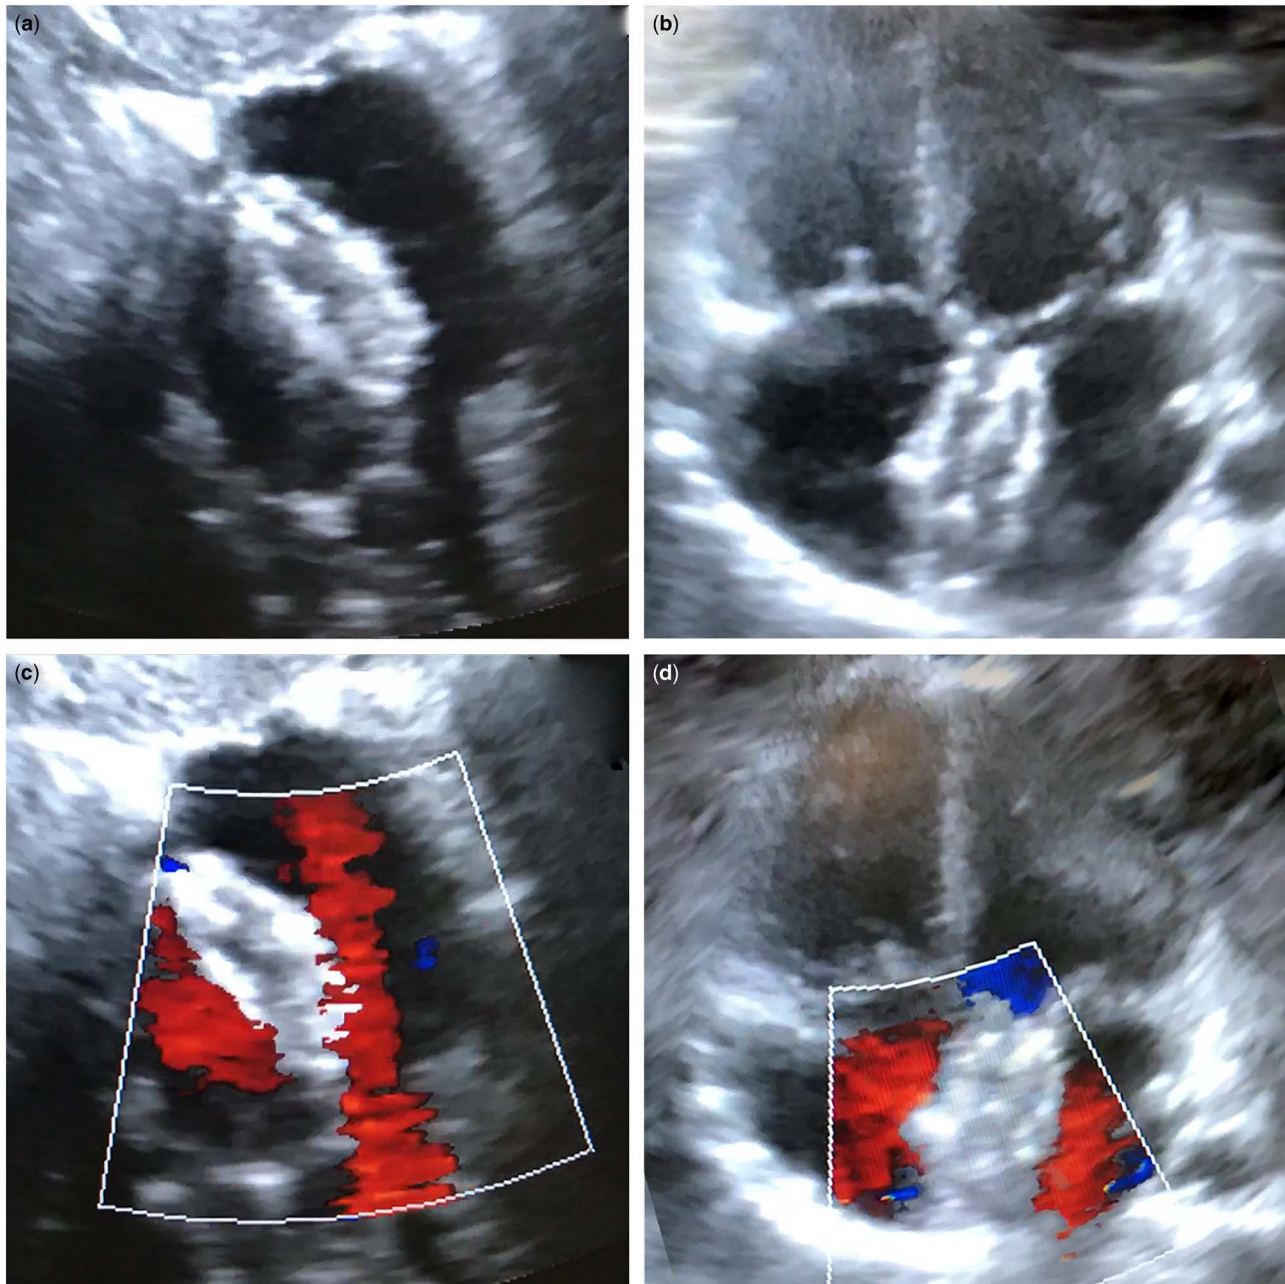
Transthoracic echocardiogram. (a, b) Two-dimensional echo shows complete device integrity. (c, d) Color Doppler echo. No perforations observed.
